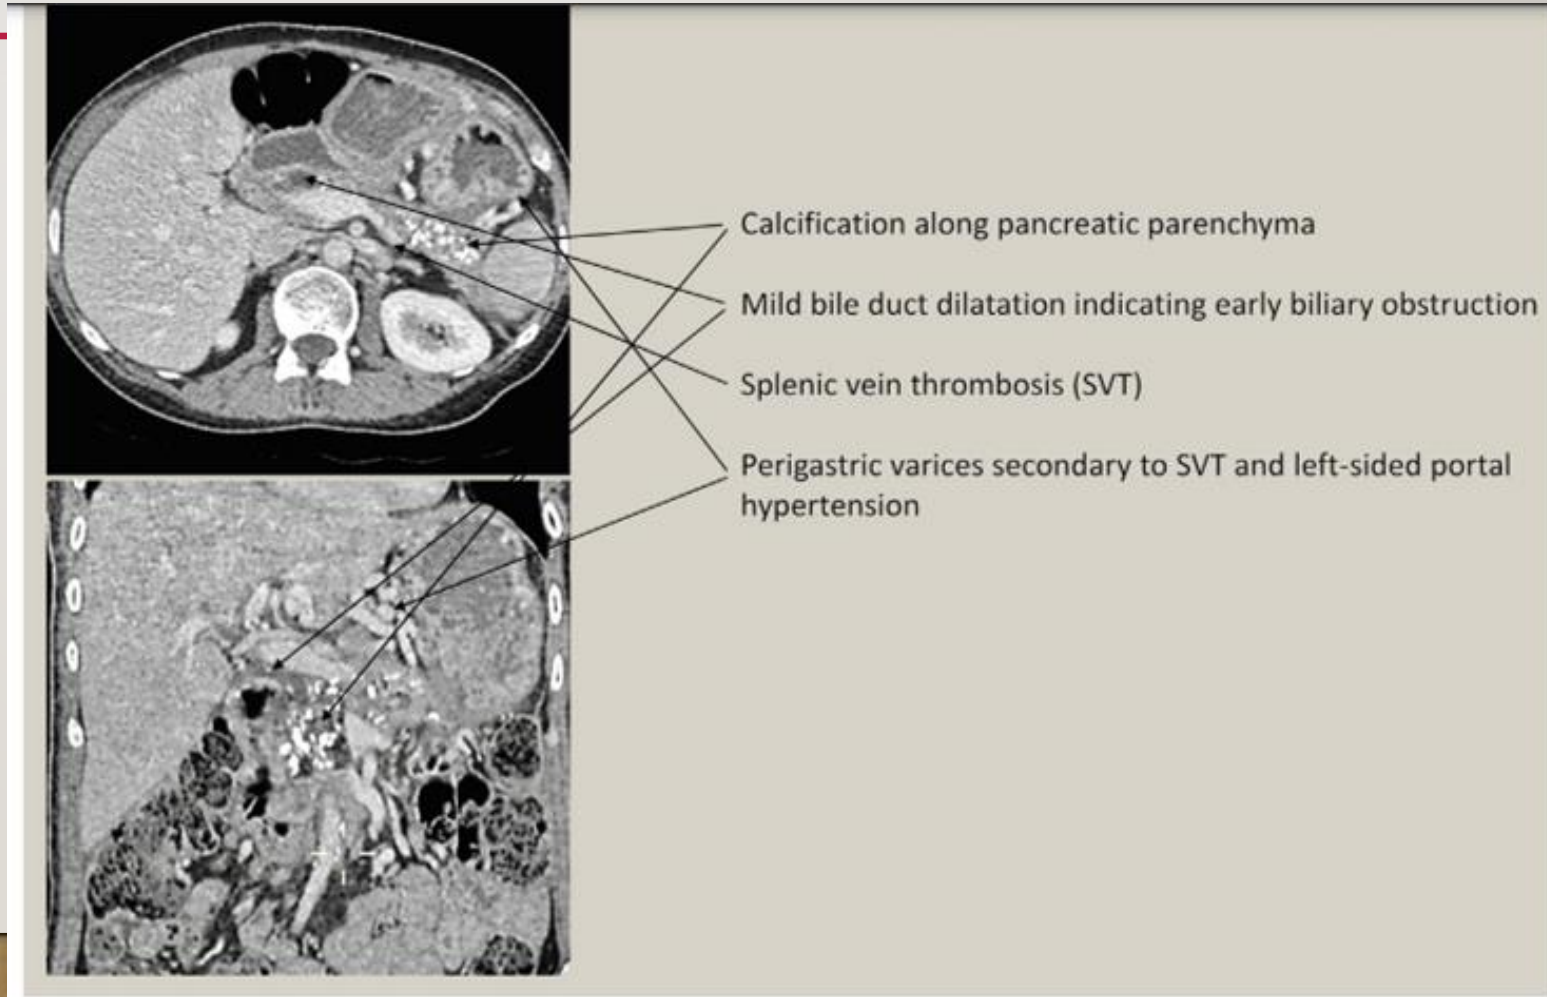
Axial and coronal reconstruction of a CT scan of a patient with chronic pancreatitis.
